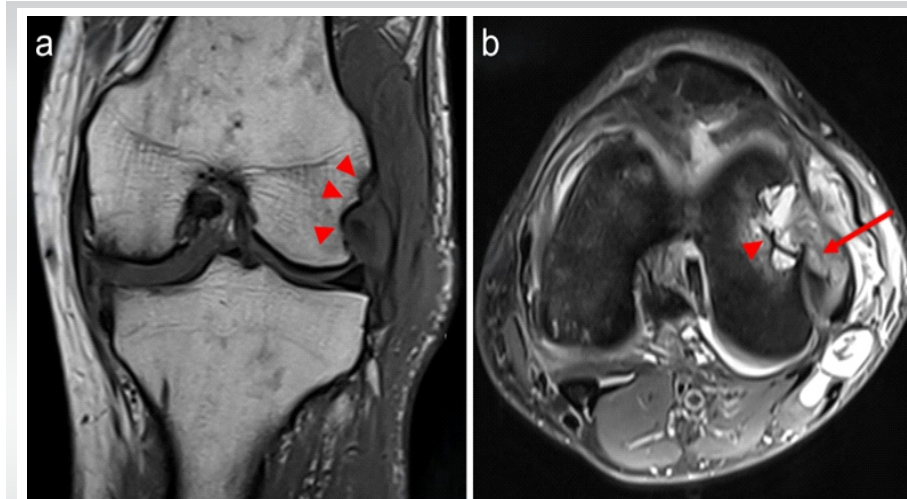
(a) Coronal T1-weighted MRI of the left knee demonstrates a low signal intensity soft tissue lesion along the lateral aspect of the knee, closely related to the popliteus tendon, with associated cortical erosion of the lateral femoral condyle (arrowheads). (b) axial T2-weighted image demonstrates a diffusely thickened intra-articular popliteus tendon with intermediate signal intensity and an infiltrative appearance (arrow). Subjacent cortical erosions of the lateral femoral condyle are noted at the level of the popliteal sulcus (arrowhead). Associated overlying bursitis and small joint effusion are also evident.
